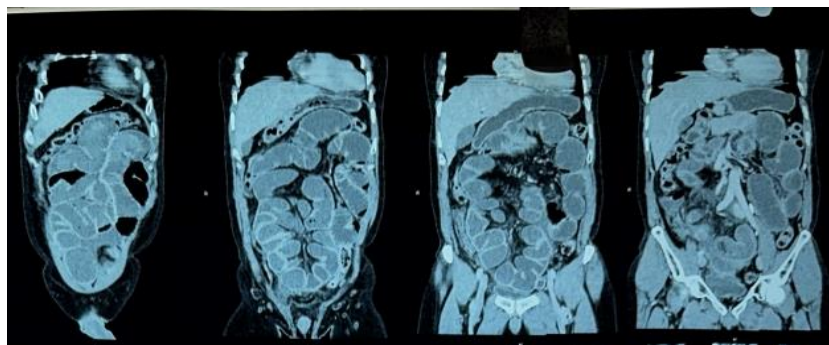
A coronal slice of the CT scan of the belly and pelvis demonstrating the intestinal loops' matting and clumping in the abdomen's center. Loops are embedded in a thin-walled sac that has localized fluid collection; the sac usually contains the proximal portion of the jejunum and the duodenojejunal flexure
